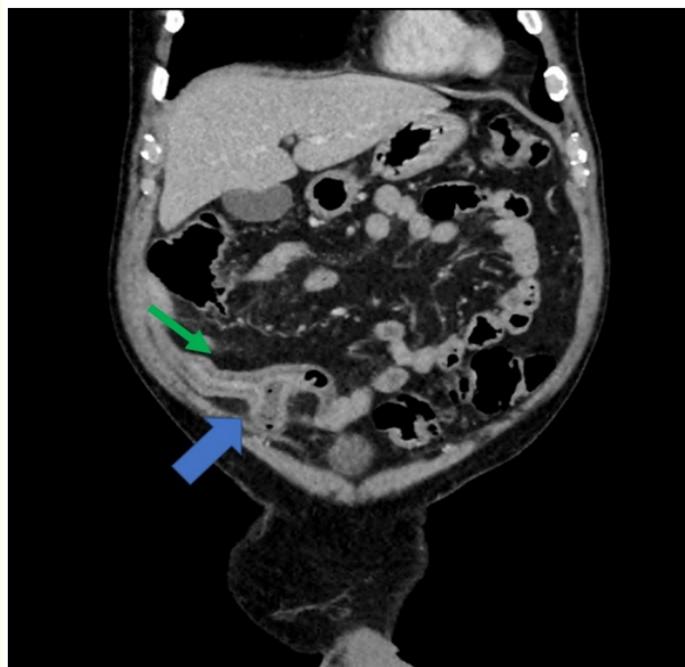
Coronal film of the CT scan demonstrating the diverticulum originating within 30 cm of the ileocaecal junction (thick arrow), representing most likely a Meckel's diverticulum. It is fluid-filled with a moderately thickened wall and there is surrounding inflammatory stranding in the adjacent fat (thin arrow).
